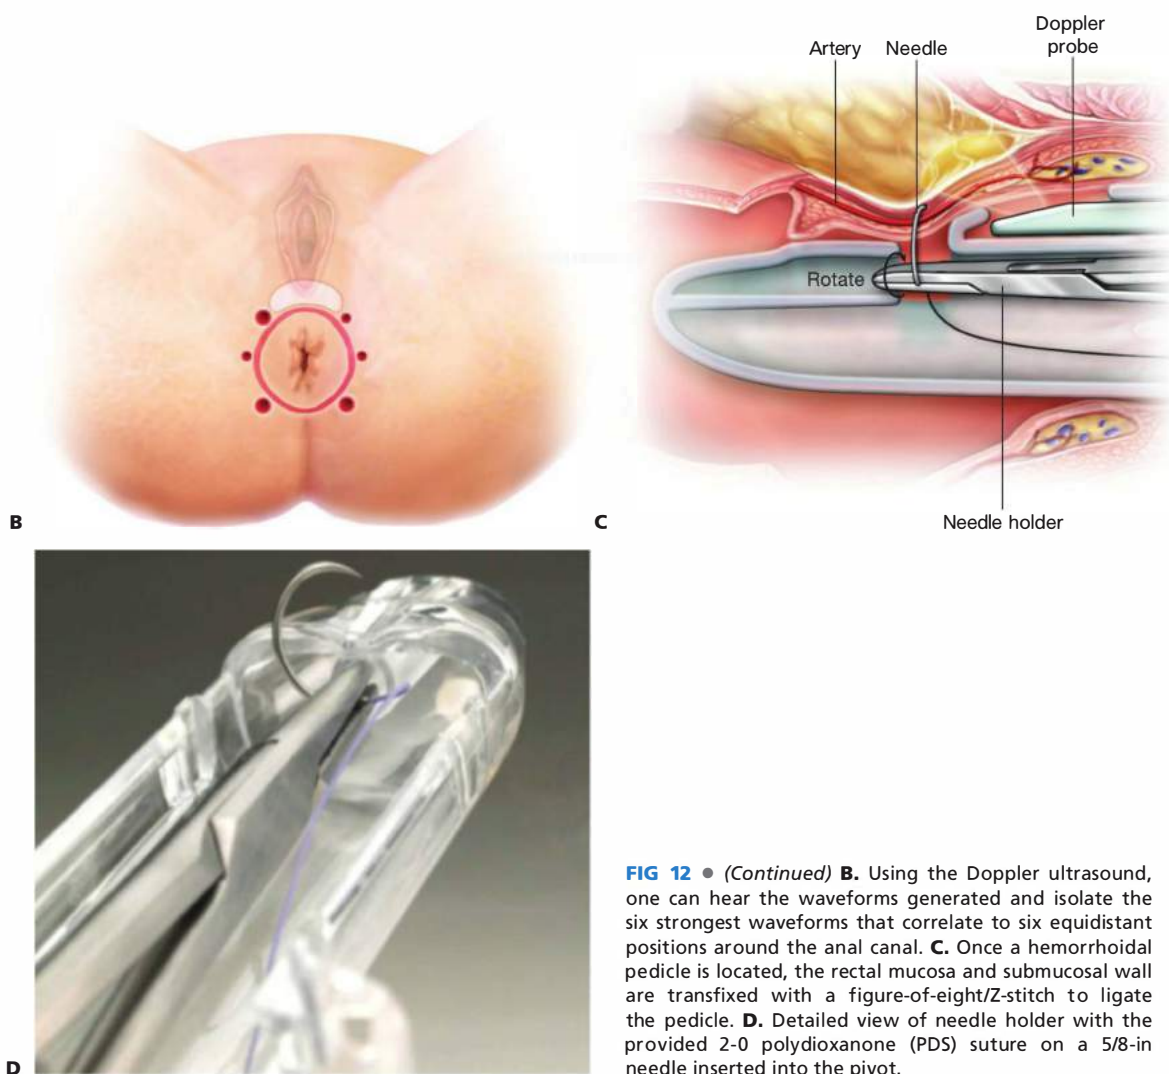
• (Continued) B. Using the Doppler ultrasound, one can hear the waveforms generated and isolate the six strongest waveforms that correlate to six equidistant positions around the anal canal. C. Once a hemorrhoidal pedicle is located, the rectal mucosa and submucosal wall are transfixed with a figure-of-eight/Z-stitch to ligate the pedicle. D. Detailed view of needle holder with the provided 2-0 polydioxanone (PDS) suture on a 5/8-in needle inserted into the pivot.
